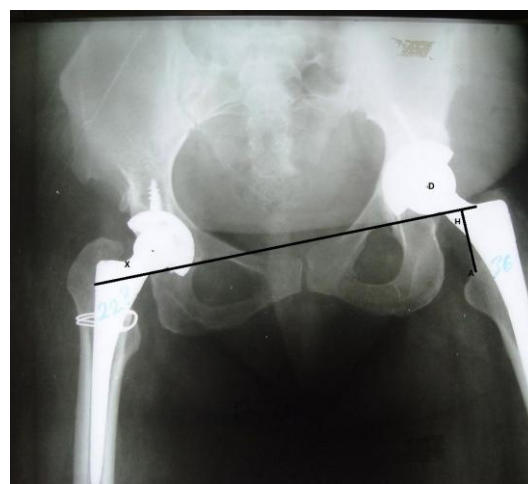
Anteroposterior pelvic radiograph of a patient after bilateral hip arthroplasty showing measurement of the leg length relative to the interteardrop line. Line 'x' represents the inter-teardrop line and line 'AH' is the perpendicular from the highest point of the lesser trochanter. Measurements are calibrated using the known diameter of the prosthetic femoral head (D) as reference. The distance 'AH' will be compared to the corresponding measurement on the preoperative radiograph to calculate the amount of length change.
